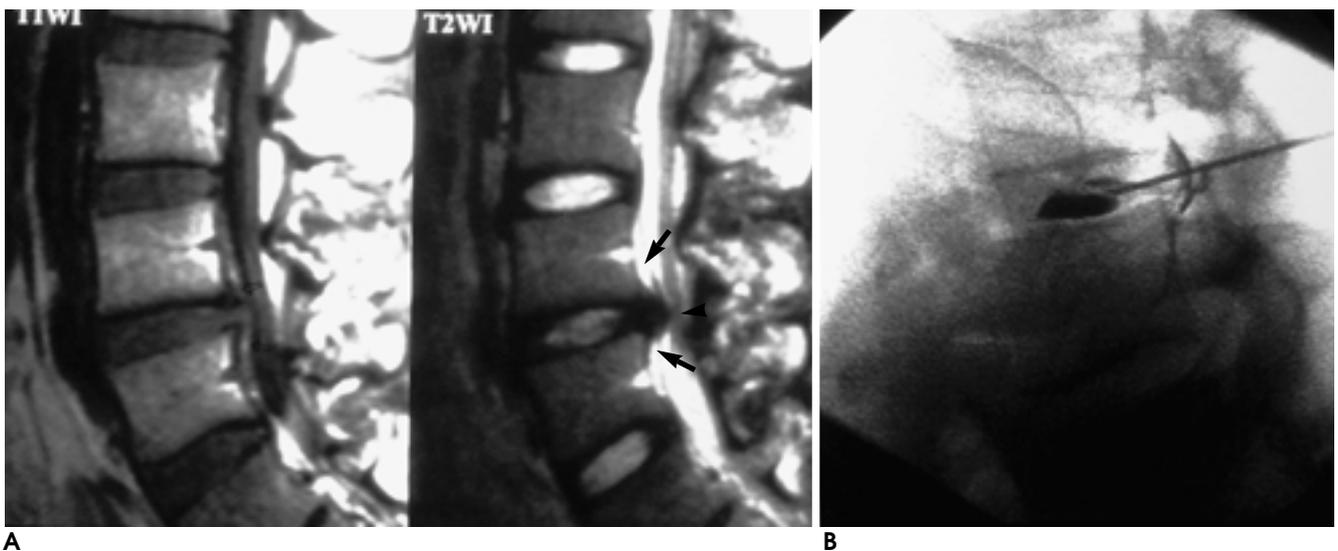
A 22-year-old male patient with an extruded disc. Sagittal T1-weighted turbo spin-echo image (600/12) (left) shows low signal intensity change (black arrow) at the anterior epidural space around the L4-5 disc, compared with high signal intensity at the anterior epidural space of the S1 level (open arrow). Sagittal T2-weighted turbo spin-echo image (4000/112) (right) reveals an extruded disc at the L4-5 level, with the interruption of solid dark line (arrow head) and high signal intensity at the anterior epidural space (black arrow).
